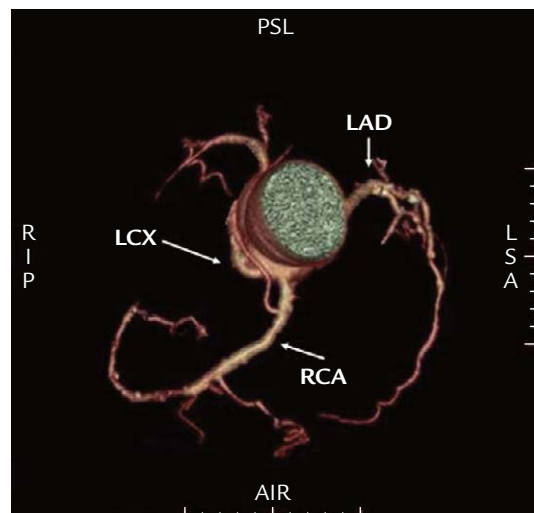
Type V coronary artery anatomic variant as shown on 64-multidetector-row computed tomography. The right coronary artery (RCA) and left circumflex artery (LCX) originate from sinus 2. The left anterior descending artery (LAD) originates from sinus 1.
